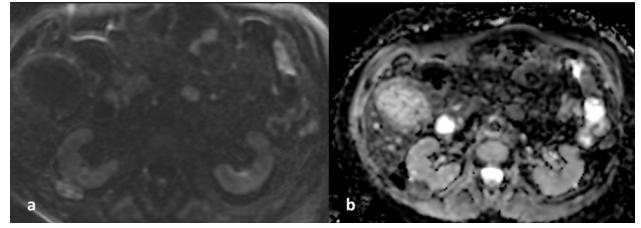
DWI – b 1000 (a) and ADC map (b)
